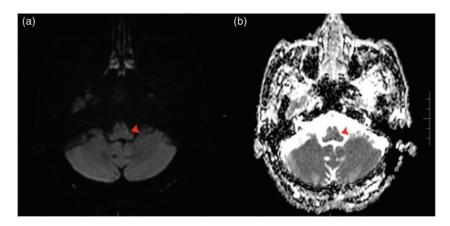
Brain magnetic resonance imaging showing high signal intensity on diffusion-weighted imaging and low signal intensity on apparent diffusion coefficient imaging, suggesting an acute or subacute cerebral infarction in the medulla oblongata.
